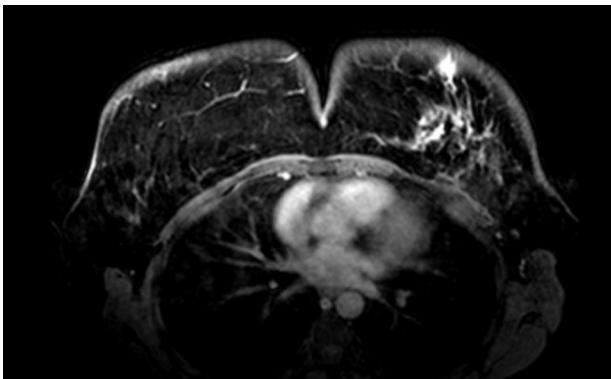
Post induction chemotherapy MRI.
